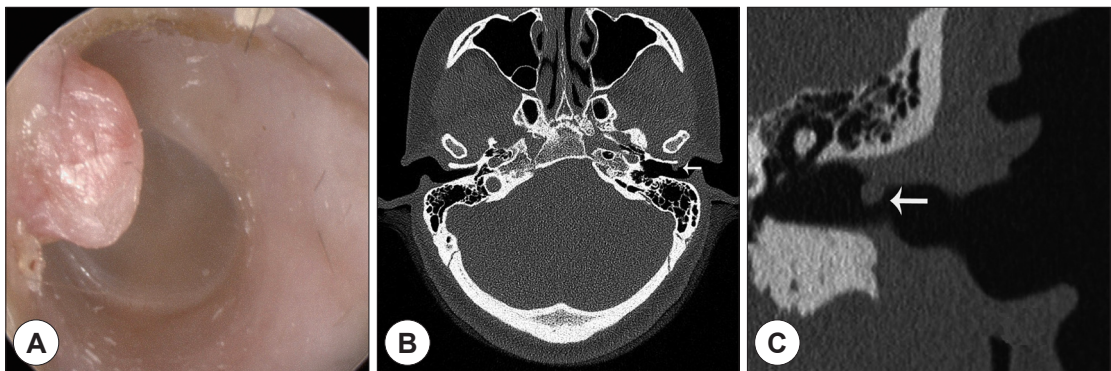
A : Otoscopic findings show that the tumor is located on the anterior wall of the left external auditory canal. B : A computed tomography scan of temporal bones shows a mass (arrow) of a 3×4 mm-sized soft tissue density in the left external auditory canal (EAC). C : A coronal image shows a soft tissue density mass (arrow) in the left EAC, the tympanic membrane is normal, and no bony erosion is observed.
